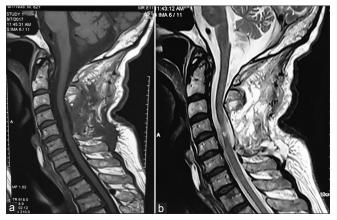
Post-op sagittal cervical MRI, (a) and (b) laminectomy and decompression of the cord is shown both in TI- and T2-weighted images
